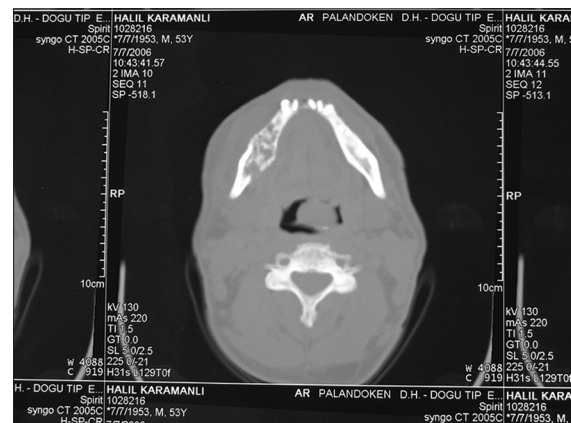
CT scans of the maxillofacial region.
